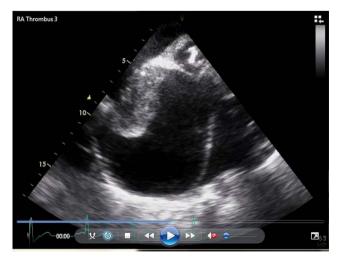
Follow-up echocardiography in 2012. The dilated right atrium shows a large right atrial thrombus that has not changed much over the years.
